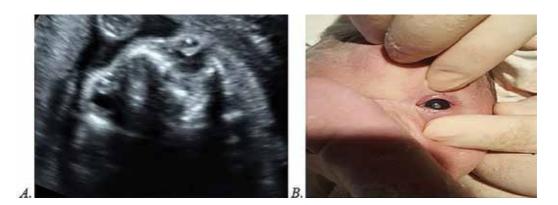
A. Sonographic pictures of fetal cataracts at 24 weeks of gestation. Coronal views of echogenic lens. B. The postnatal aspect of the lens.
